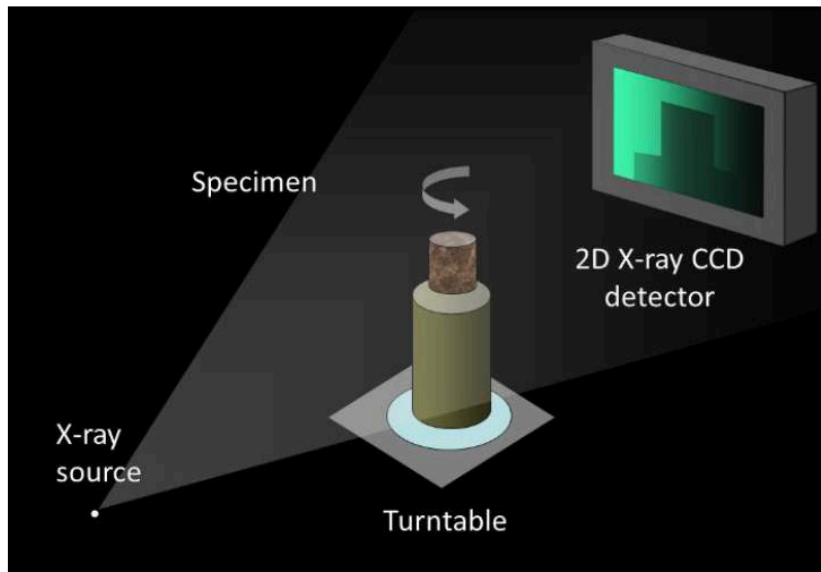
Image to demonstrate X-ray Microtomography (XMT) set-up.
